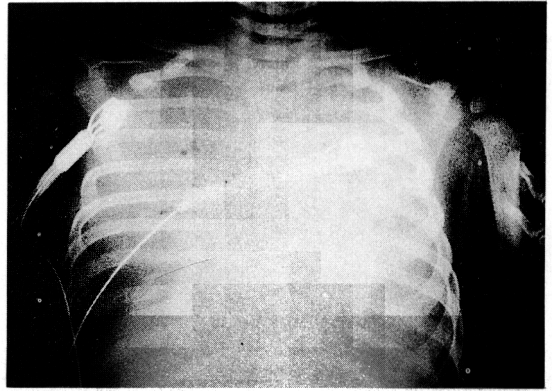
A chest x-ray of this case on the 7th hospital day shows total haziness on both lung fields.
